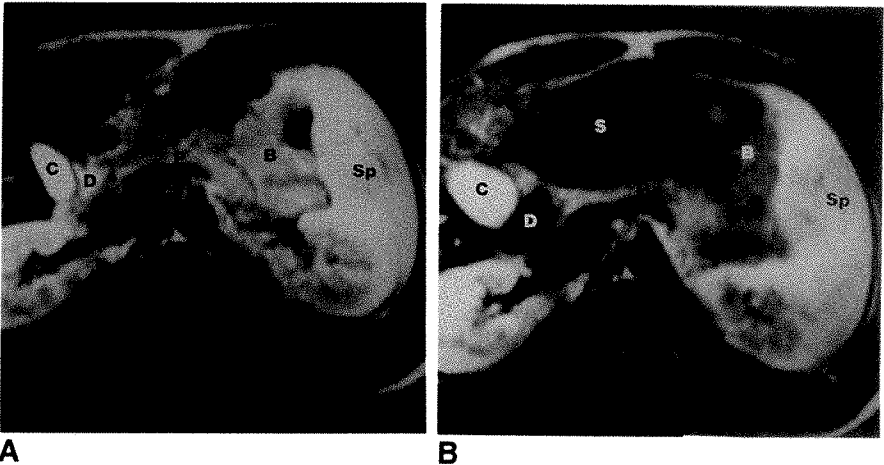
Superparamagnetic iron oxide administered as oral contrast agent. SE 2350/60 (1.5 T) MR images.
